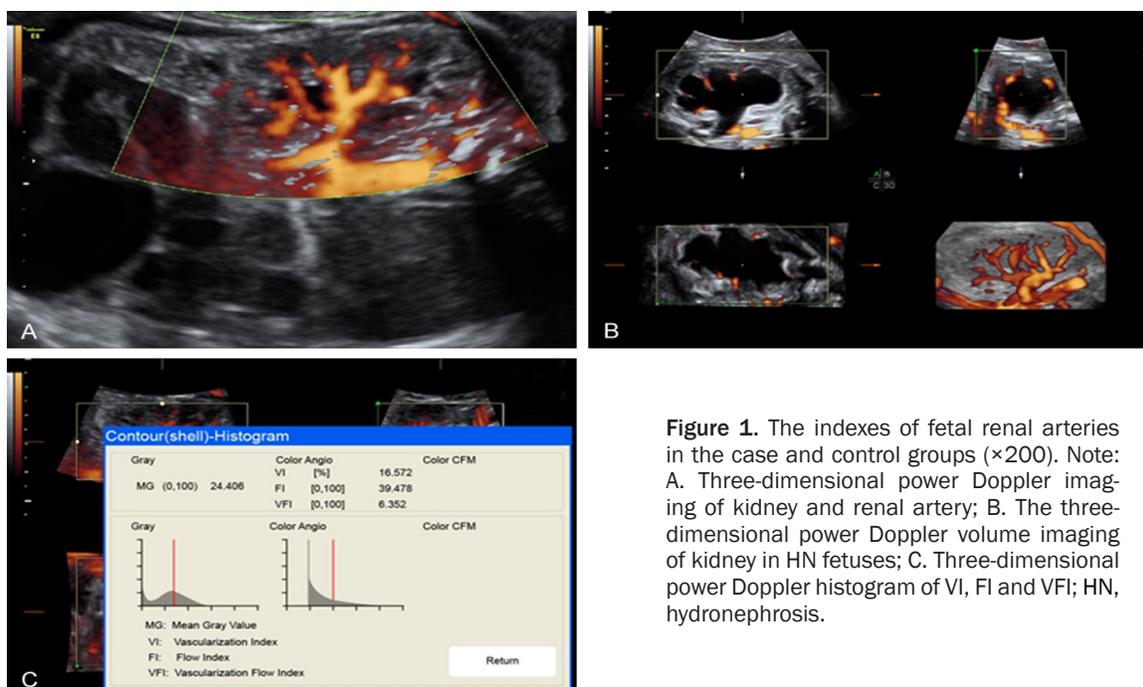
The indexes of fetal renal arteries in the case and control groups ($\times 200$). Note: A. Three-dimensional power Doppler imaging of kidney and renal artery; B. The three-dimensional power Doppler volume imaging of kidney in HN fetuses; C. Three-dimensional power Doppler histogram of VI, FI and VFI; HN, hydronephrosis.
